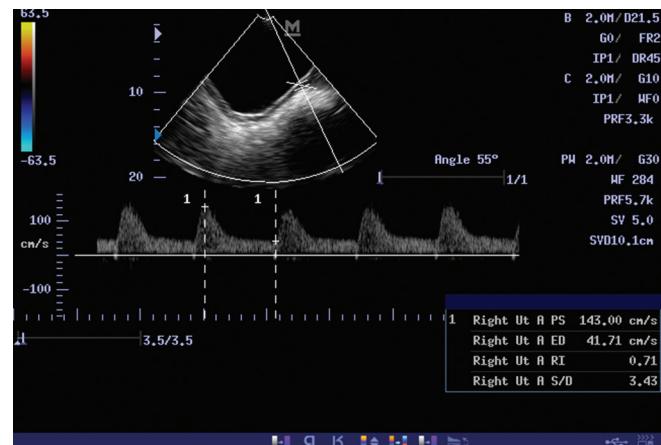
Duplex Doppler sonogram of the right uterine artery of one of the hypertensive patient, showing the peak systolic velocity of 143.0 cm/s and resistance index of 0.71
